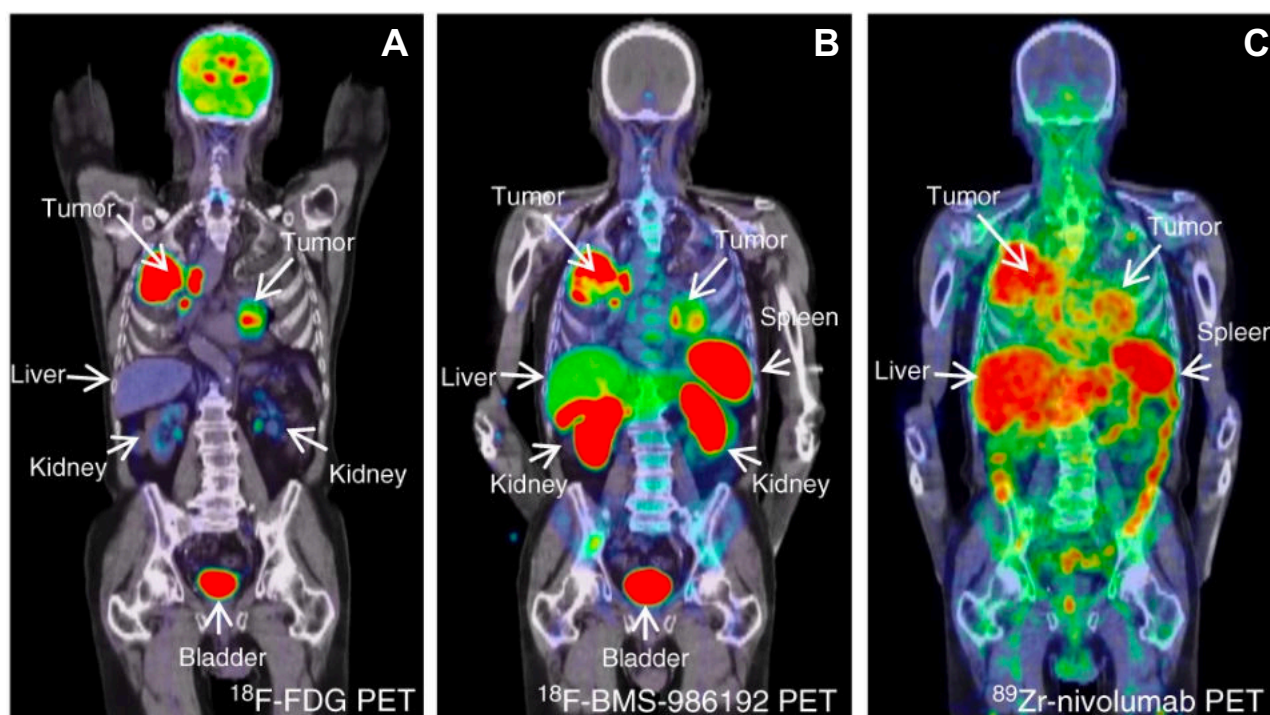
PET/CT fusion images of a patient with PD-1/PD-L1 positive tumour. (A) [^{18}F]-FDG PET (225 MBq) demonstrates high glucose metabolism of tumours in both lungs and mediastinal lymph nodes, (B) [^{18}F]-BMS-986192 PET (145.7 MBq, imaging time point 1 h post-injection (p.i.)) and (C) ^{89}Zr -labeled Nivolumab PET (37.09 MBq, 162 h p.i.) demonstrate heterogeneous tracer uptake within and between tumours. Figure copyright from [110].
